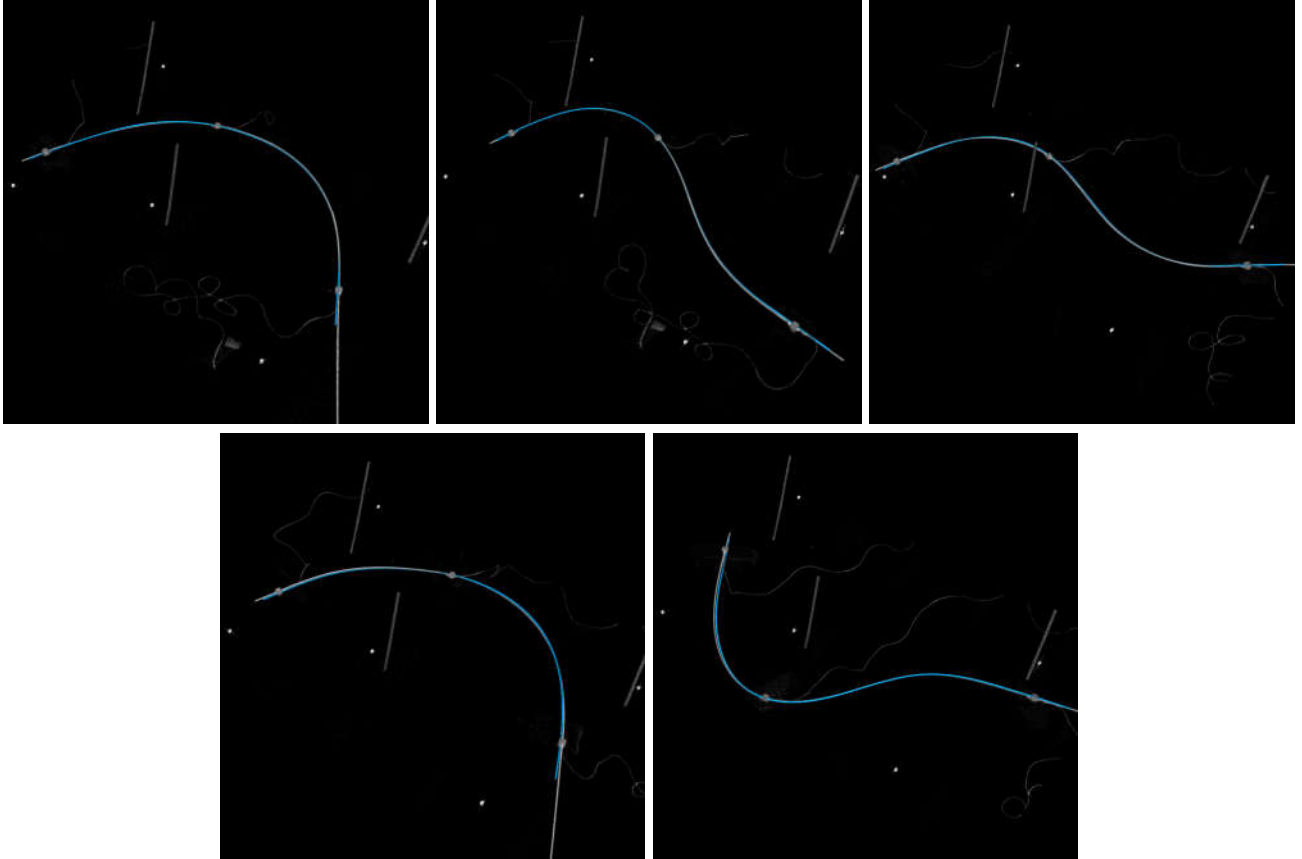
CT scans of each experiment with displayed located shapes (blue): Bow, Curve, S-Curve, 3D Bow, 3D Curve (from left to right, from top to bottom).
